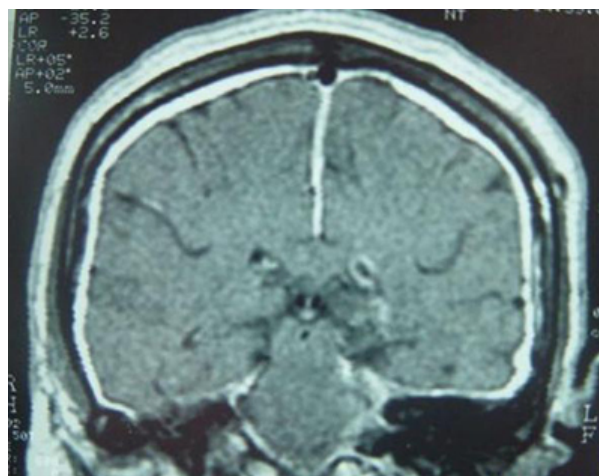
Contrast-enhanced T1-weighted coronal MR image shows diffuse thickening and contrast enhancement of dura mater
